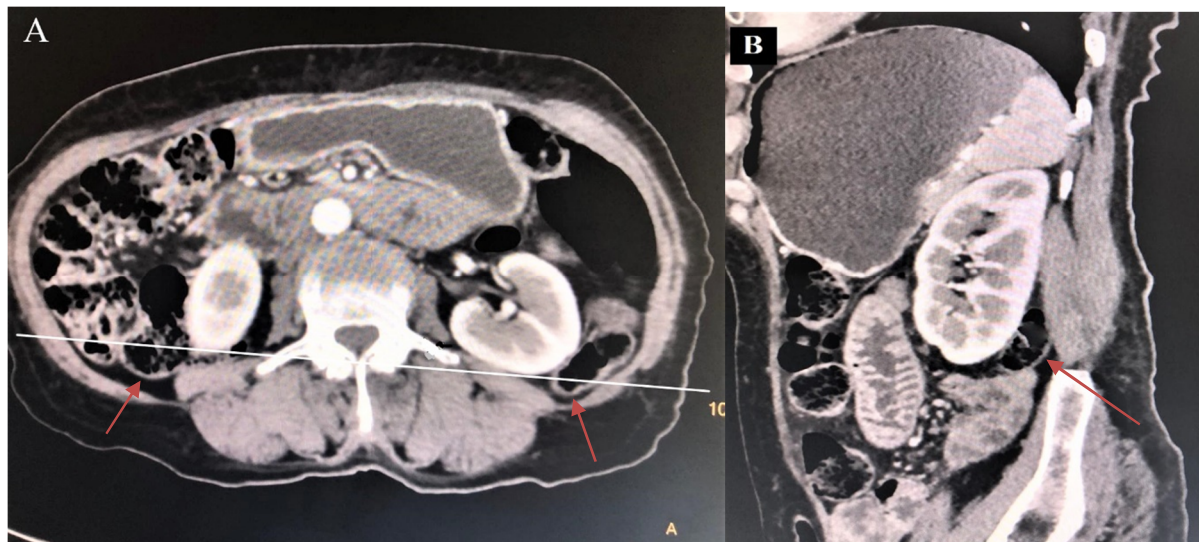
CT images of retrorenal colon: A, Cross section CT shows the bilateral posterior location of the colon to the line drawn between the posterior surfaces of both kidneys. B, Sagittal section CT image shows the posterior position of the colon to the lower pole of the kidney.
